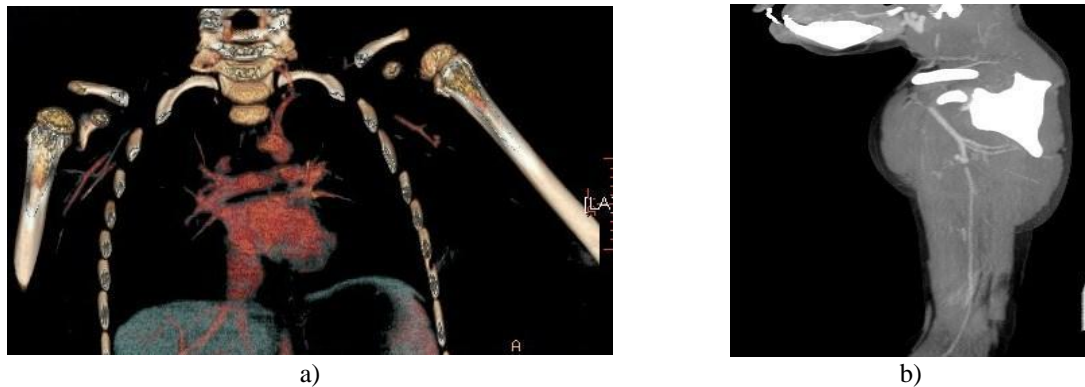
CTA with 3D construction; Small pseudo-aneurysm at the left axillary artery with complete disruption; with flow reconstruction distally to the brachial artery by collaterals, showing lighter contrast at the distal vessels compared to the proximal axillary artery
